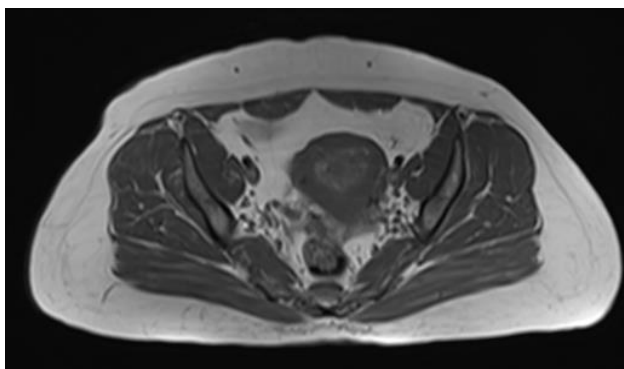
Axial T1 weighted MRI pelvis pre-contrast image.
